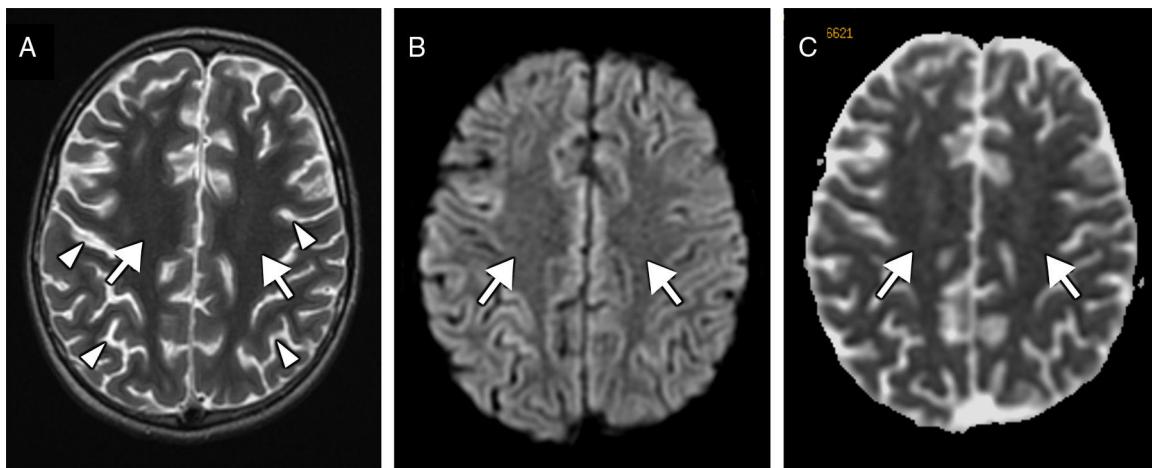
Follow-up MRI scan performed at 3 weeks. The transverse T2-weighted sequence (A) reveals normalised signal intensity in the white matter (arrows) and moderate loss of volume with more prominent sulci (arrowheads). Diffusion restriction (arrows) is no longer observed on the diffusion sequence (B) and corresponding apparent diffusion coefficient maps (C).
